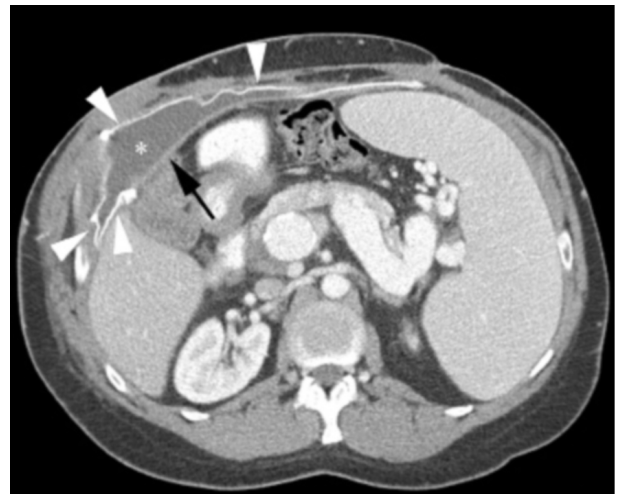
Companion case. Enhanced axial CT through the upper abdomen in a different patient with a seroma (\*) deep to hernia repair mesh (arrowheads) and an enhancing wall of granulation tissue (arrow) between the seroma and abdominal cavity. Additional findings of splenomegaly with prominent varices and portosystemic shunts in the splenic hilum and peripancreatic region are sequelae of portal venous hypertension prior to hepatic transplantation.
